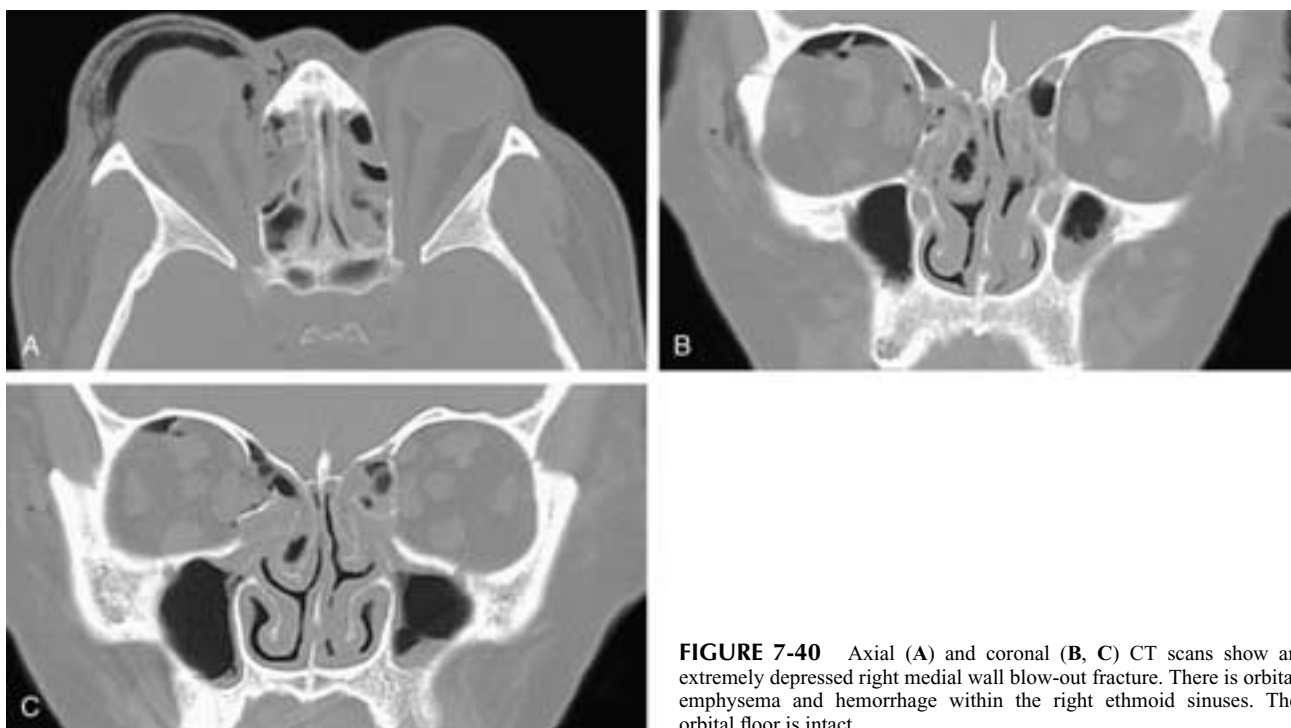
Axial (A) and coronal (B, C) CT scans show an extremely depressed right medial wall blow-out fracture. There is orbital emphysema and hemorrhage within the right ethmoid sinuses. The orbital floor is intact.
